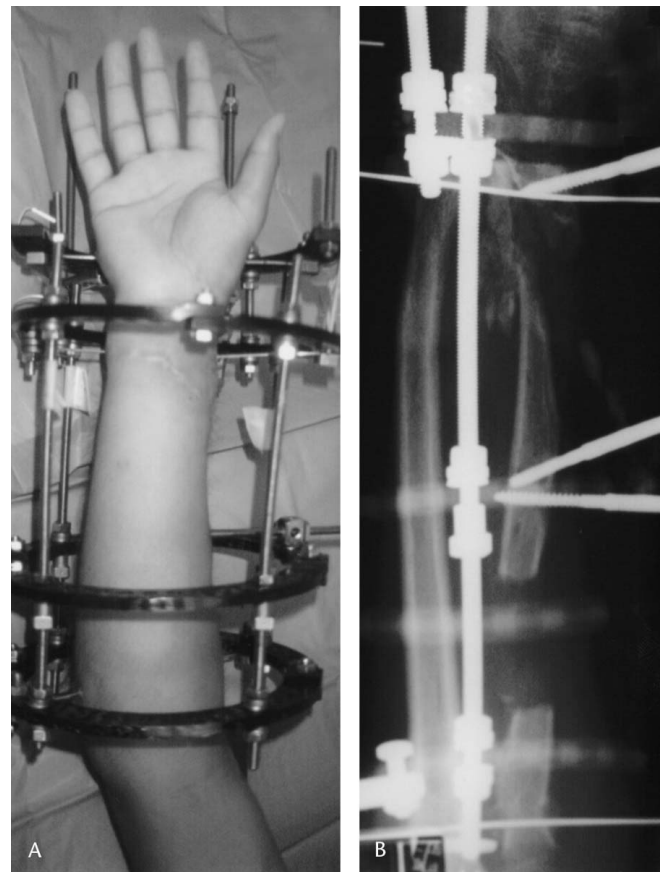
(A) A photograph and (B) radiograph show that after gradual correction of the deformity through the atrophic nonunion, a 4.1-cm proximal to distal bone transport of the radius and subsequent autogenous bone graft of the distal docking site was done (Case 1).
